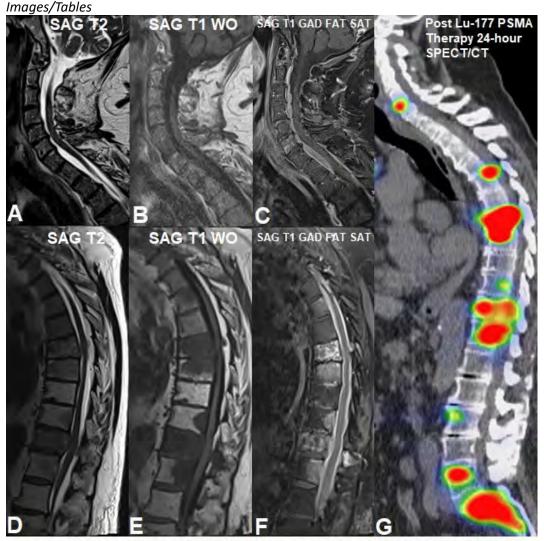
Sagittal T2-weighted images of the cervical (A) and thoracic (B) spine demonstrate a T2 hyperintense and T1 hypointense (C, D) dural effusion. Sagittal post-contrast fat-saturated T1-weighted images show enhancement of the effusion (E, F). Post Lu-177 PSMA therapy 24-hour SPECT/CT image demonstrates Lu-177 PSMA localization to known bone metastases, with no evident uptake in the dural effusion (G).
